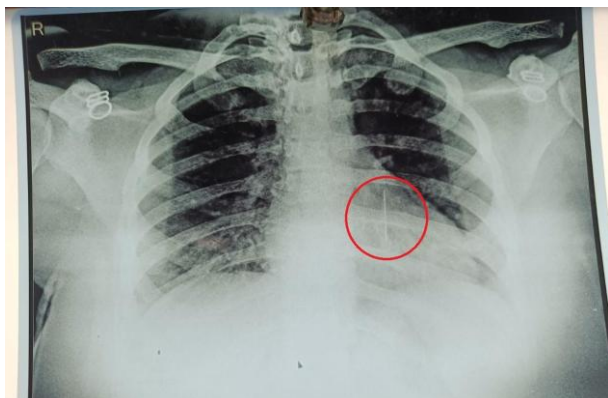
Chest X-ray showing scarf pin in left bronchus.
